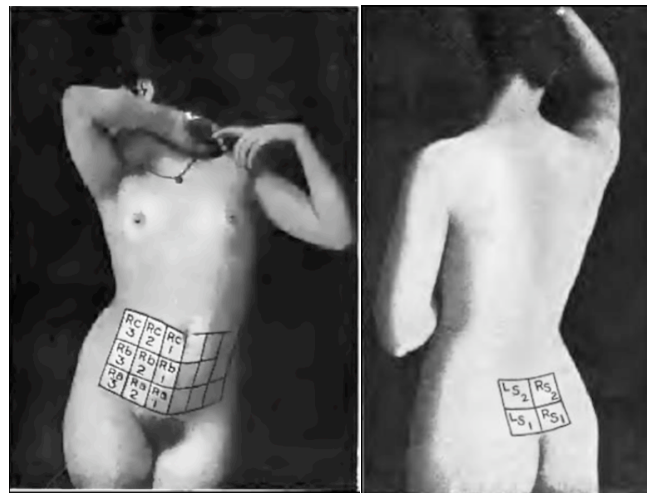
Grid on patient showing areas irradiated in x-ray treatment of uterine fibroids.³⁵¹
